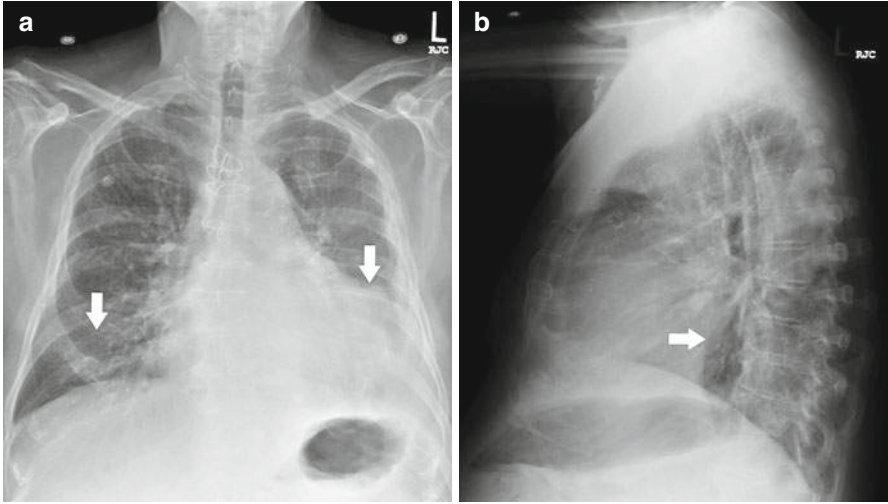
Aspiration pneumonia. Chest X-ray posteroanterior (a) and lateral (b) views show pneumonia (arrows) bilaterally in the lower lobes
